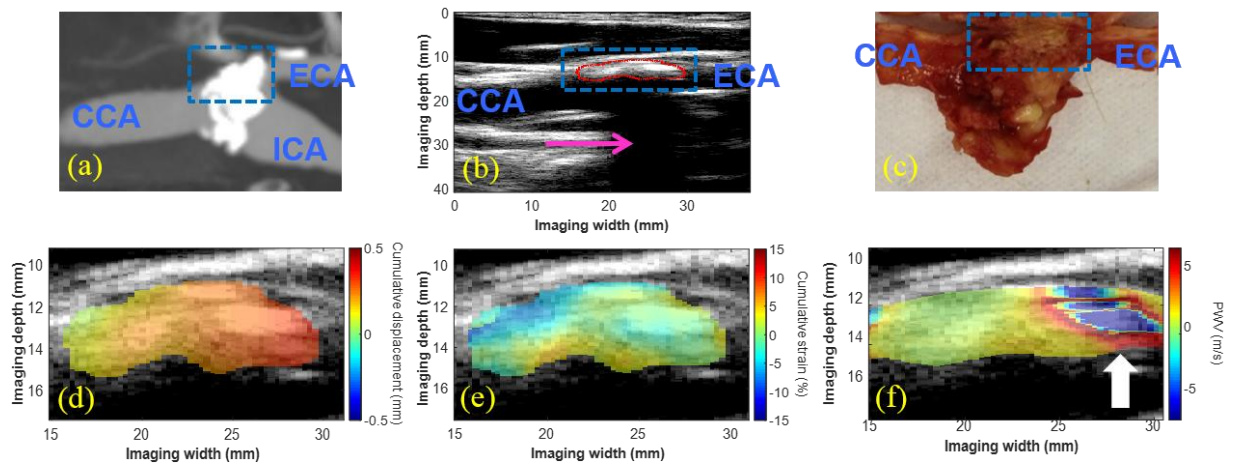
(a) CTA showing a severely-calcified, high-grade stenosis (80-99%) at the carotid bifurcation in an 80-y.o. male generating a severe acoustic shadow (pink arrow in b). A highly-calcified white nodule was identified on the gross pathology image (blue dashed box in c), correlating with the echoreflexive region of the plaque on the B-mode (red contour in b). The intra-plaque displacement (d) and strain (e) maps revealed regions of varying displacement and strain amplitude, while the intra-plaque PWV map showed a region of alternating positive and negative PWVs throughout the depth of the plaque at the distal end (white arrow in f).
